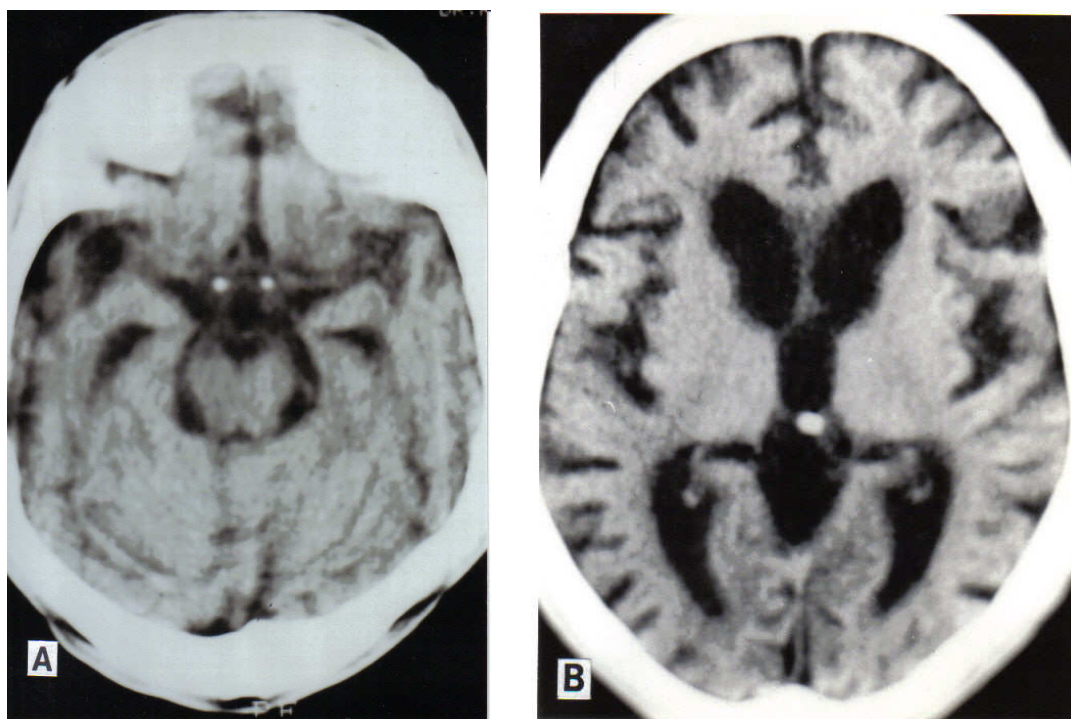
A. CT scan without contrast showing atherosclerosis of the circle of Willis and proximal segments of the anterior and middle cerebral arteries in a 35-year-old man with familial HD.
